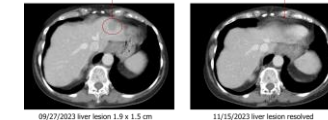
Computed tomography scans of an anti-PD-(L)1 resistant melanoma patient showed a confirmed partial response. The patient previously received adjuvant ipilimumab and Nivolumab, and metastatic treatments with Nivolumab, ipilimumab, Talimogene laherparepvec, and Binimetinib; all were discontinued due to complications or PD. Disease sites included the chest wall, liver, and left thigh, with non-target lesions in the ileum and breast. The last ICI treatment was given in November 2019, 3.9 years before starting E-602.
